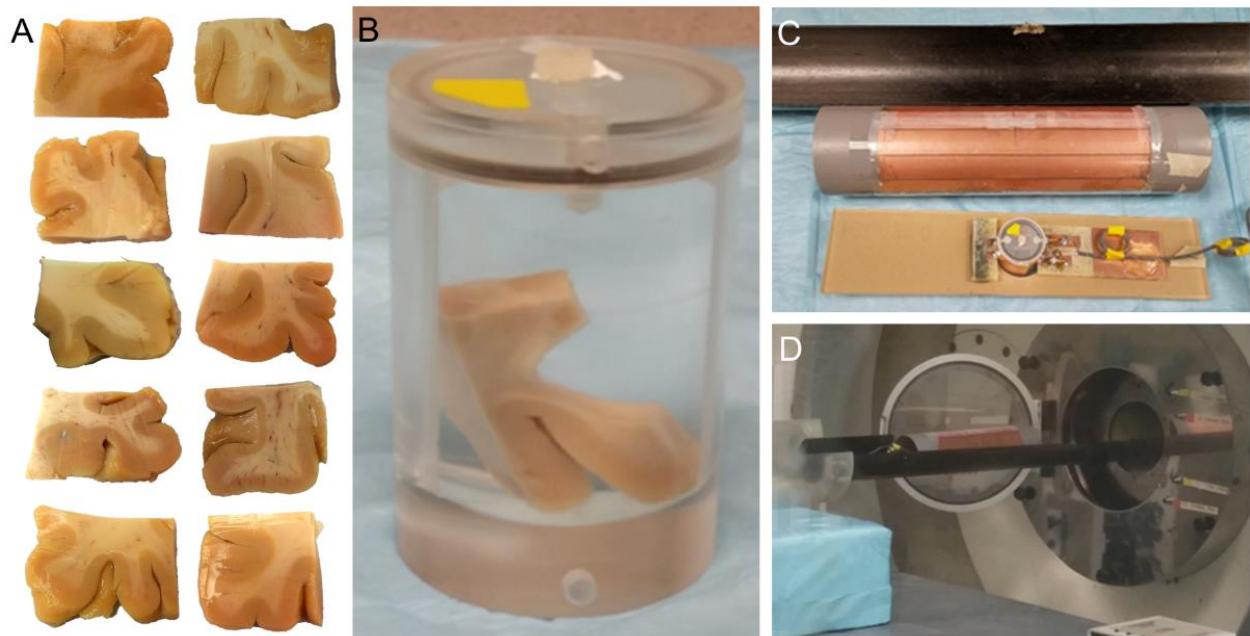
MRI data acquisition. A. Ten human *ex vivo* tissue samples from the superior frontal cortex (BA 8/9) were reequilibrated at 4° Celsius in 1xPBS with 0.01% NaN₃ for two weeks after being received from Boston University. Prior to MRI data acquisition, tissue was stored overnight at room temperature in Fluorinert. B. Tissue was placed in a container which optimized filling factor thereby maximizing the tissue signal. C. An inductive coupling coil was used in order to better tune the coil and tissue contained contents to the resonant frequency of the MRI scanner. D. GQI data were acquired in an 11.74 T Agilent MRI scanner, requiring a total scan time of 11 hours per tissue sample.
